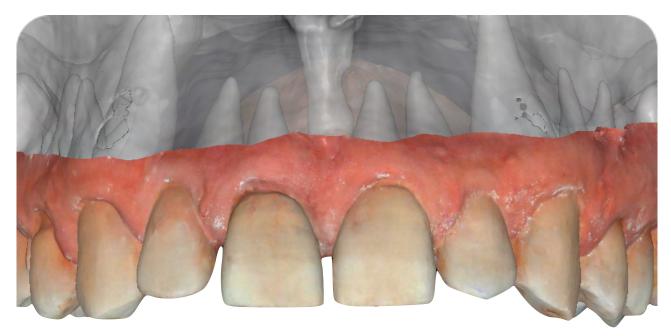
Screenshot of upper intral-oral scanning superimposed with CBCT segmentation . (Buccal view)
